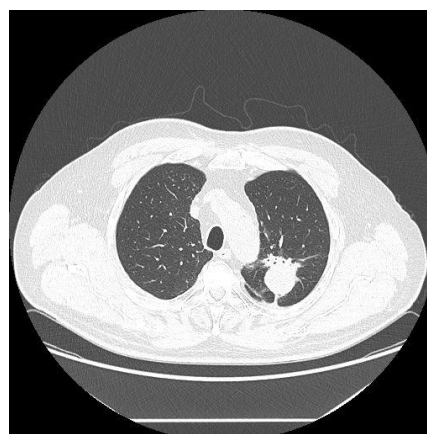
Computed tomography scan of lung (11/2022) – re-enlargement of nodular lesion in upper lobe of left lung to $37 \times 30 \times 20$ mm.
